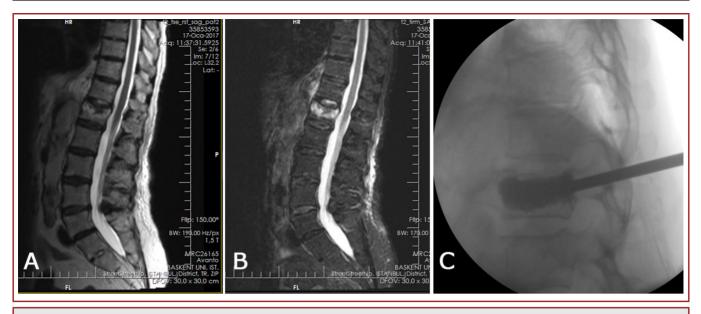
A) Preoperative T2A and B) STIR magnetic resonance images of a patient with L1 compression fracture, C) Lateral intraoperative C-arm image of the same patient.
